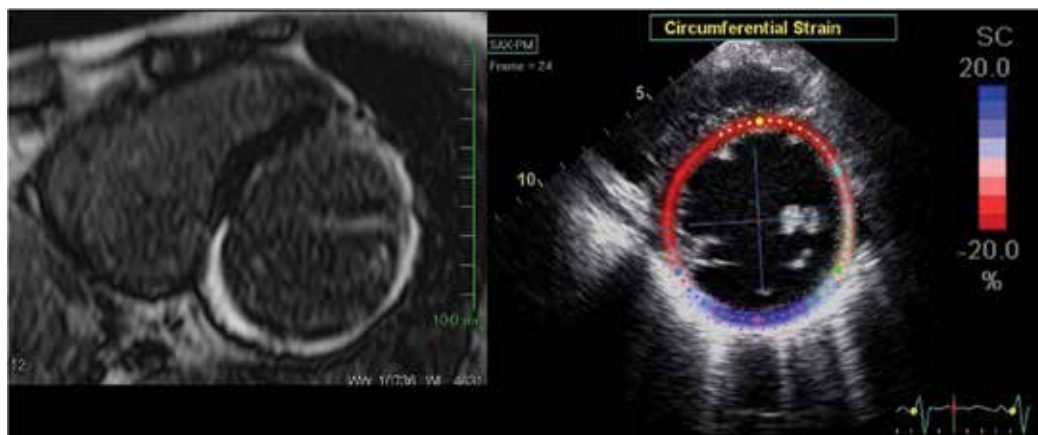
Late gadolinium enhancement of cardiac magnetic resonance imaging (in the left panel) and two-dimensional speckle-tracking echocardiographic imaging (in the right panel) in a representative case with ischemic cardiomyopathy. Severe ischemic injury and a suggestion of fibrotic change (a tissue characteristic) are depicted in the lateral, posterior, and inferoseptal segments by late gadolinium enhancement, while end-systolic circumferential strain of speckle-tracking echocardiographic imaging detected nearly +20% lengthening at the posterior region only (shown as dark blue). Two-dimensional speckle-tracking echocardiography could identify such transmurally injured “dyskinetic scars” (a mechanodynamic myocardial property), which is critically important in ventricular restoration tactics.
